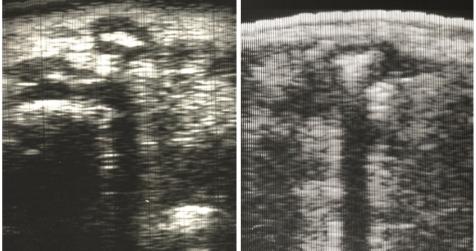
a, b With limited technical possibilities (Visodon as sonographic device) in the 1970ies discovered transverse tumour; UAS longitudinal (a, b)
